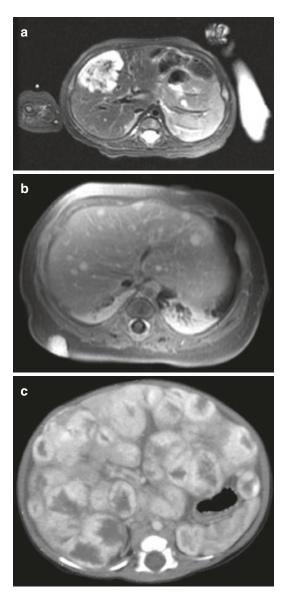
Axial MRI images of hepatic hemangioma. (a) Focal hepatic hemangioma with typical heterogenous appearance. (b) Multifocal hepatic hemangiomas dispersed throughout liver. (c) Diffuse hepatic hemangioma with near complete replacement of liver parenchyma
